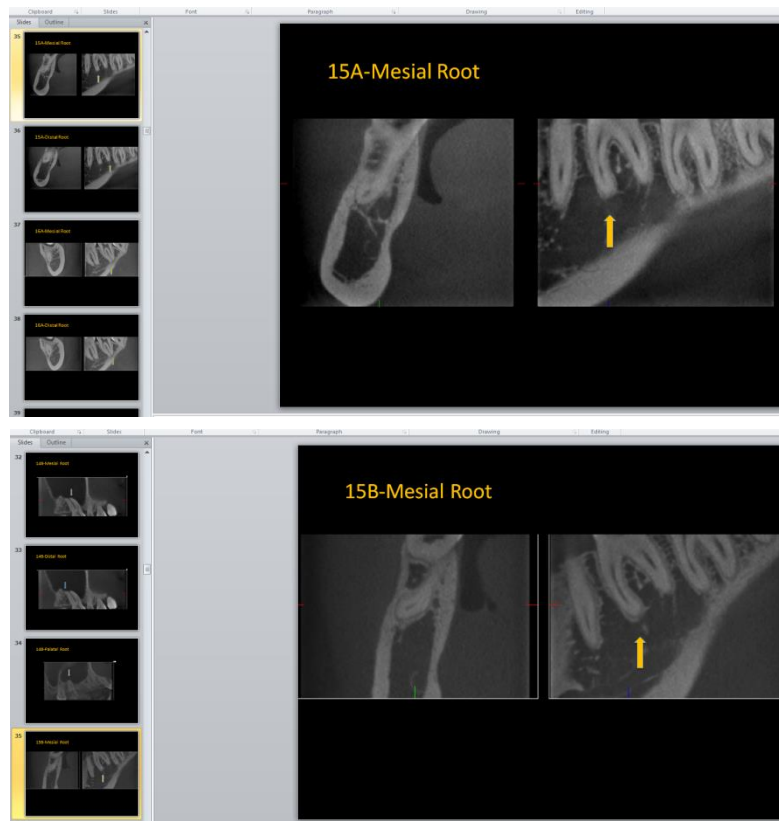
T0 and T12 CBCT images randomised to blind examiners (lower left 6)
